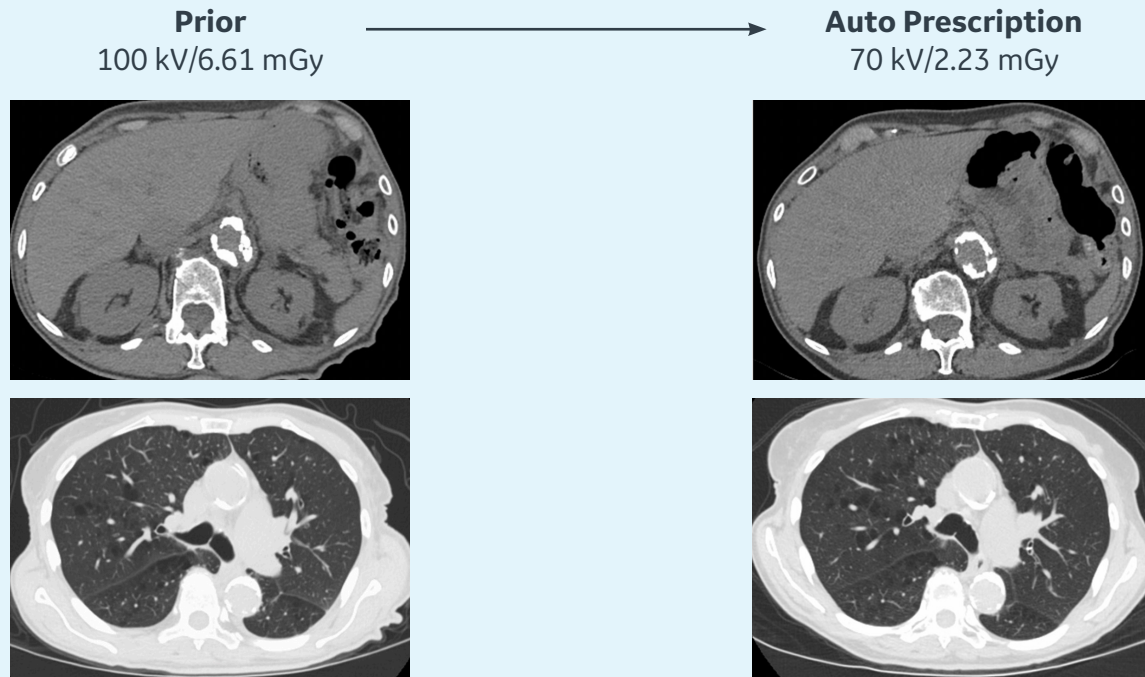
Same patient scanned on Revolution CT at 100 kV/6.61 mGy without Auto Prescription and at 70 kV/2.23 mGy with Auto Prescription (GE Thorax Profile). Both images were reviewed by a radiologist and rated above acceptable image quality. Reconstructions were performed using DLIR-M (top) and ASiR-V 0 (bottom).
